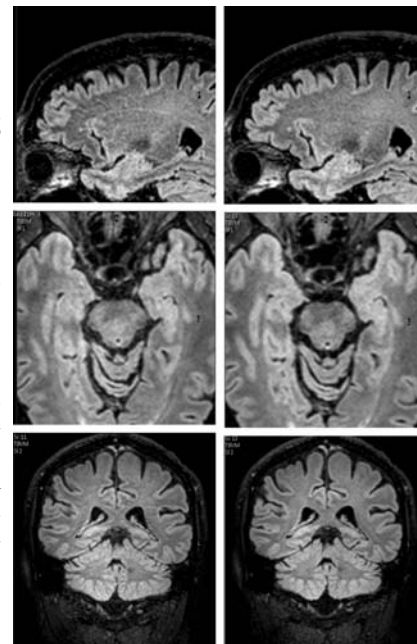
Native sagittal slice and reformatted transverse and coronal views obtained with 3D FLAIR with full TR=8s (left) and variable TR/TI (right).
